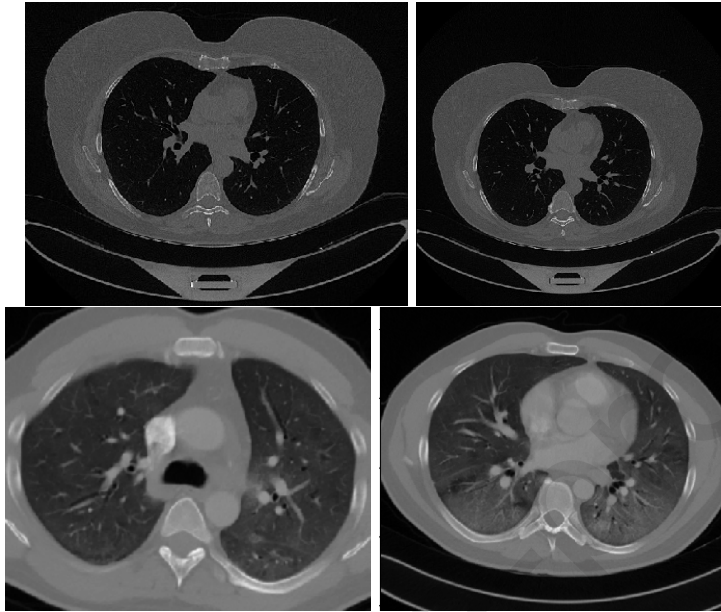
Four CT scan slices in COV19-CT-DB, the top 2 from a non-COVID-19 scan and the bottom 2 from a COVID-19, including bilateral ground glass regions in lower lung lobes.
